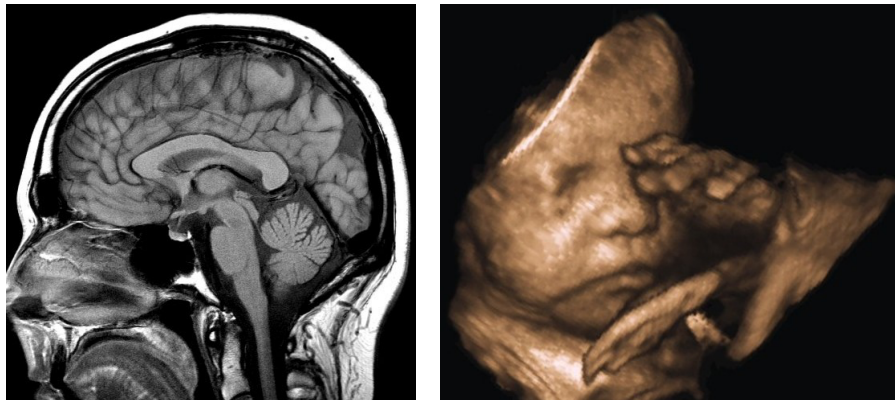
(left) MRI-scan of the brain; (right) Ultrasound of a foetus in his mother's abdomen
